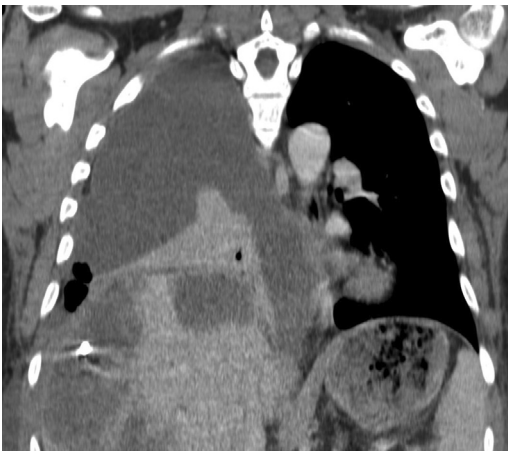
Coronal CT image of a patient diagnosed with *Entamoeba histolytica* by elevated *E histolytica* serum antibodies demonstrates multiple intrahepatic abscesses and a large loculated right pleural effusion with intrapleural gas secondary to empyema.
